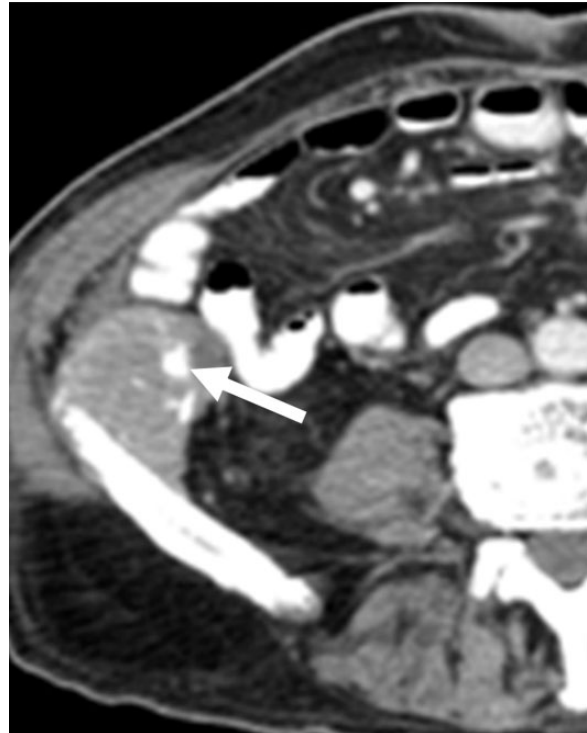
A 75-year-old man with moderately differentiated mucinous adenocarcinoma of the colon. Axial contrast-enhanced CT shows a peritoneal implant with coarse peripheral calcification (arrow), which developed while on treatment and increased with progressive disease (not shown).
